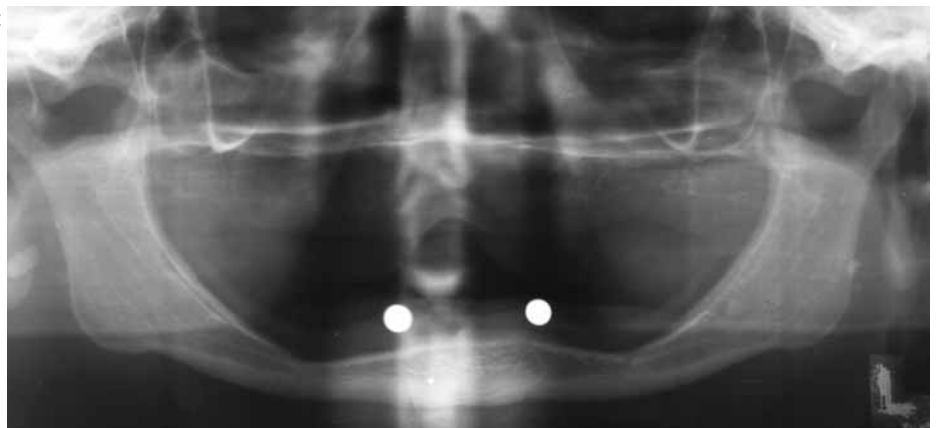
(a, b, c) A panoramic radiograph supplemented by a transymphyseal view is used to plan dental implants in the anterior mandible. In this case, 5 mm steel balls on a radiographic guide mark the proposed position of implants on the panoramic radiograph.
